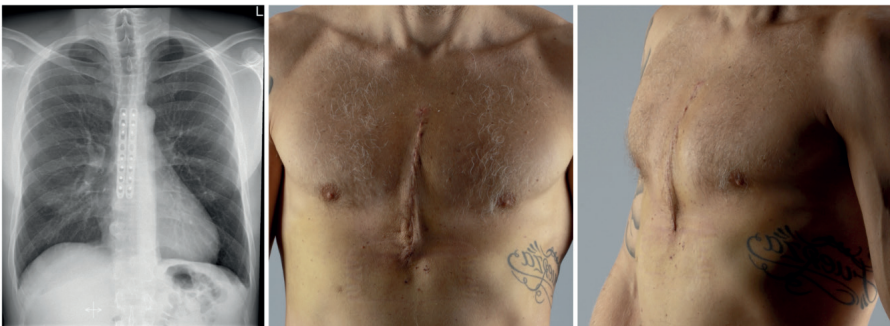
Patient C. Postoperative anteroposterior chest radiograph and optical result after modified Ravitch.
